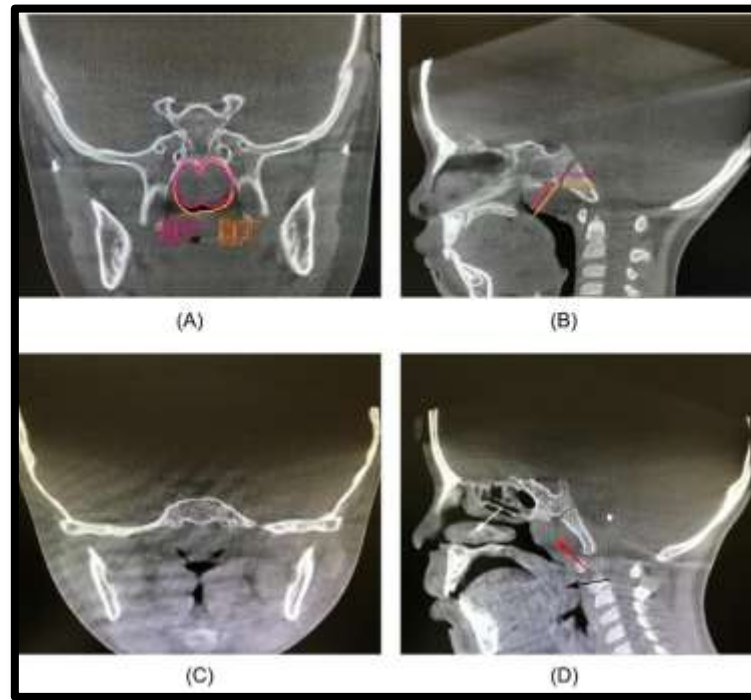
Coronal scan and sagittal reconstruction of CBCT.
